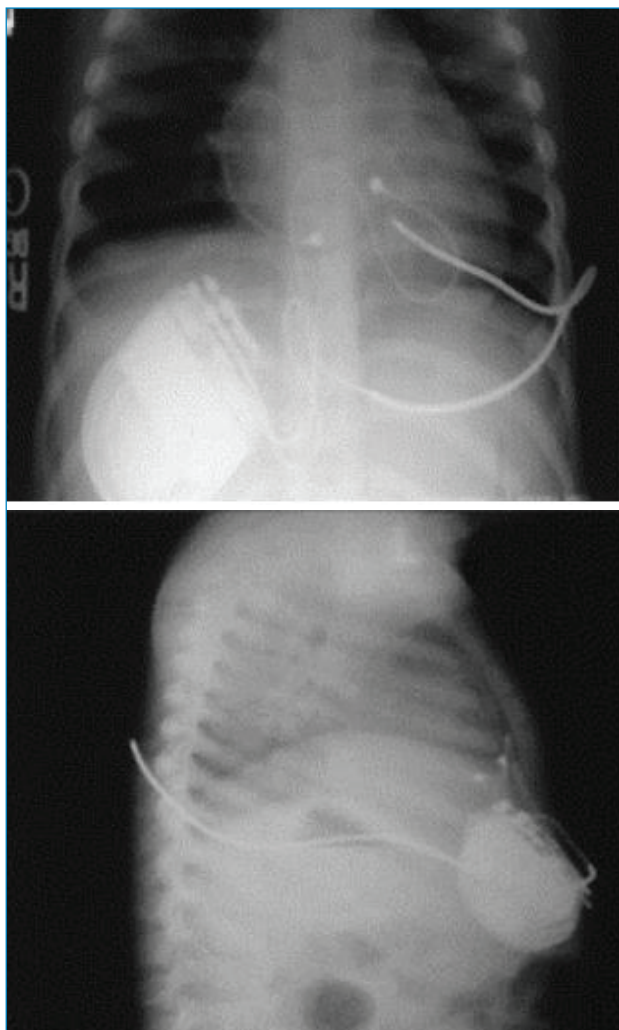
Chest radiography showing subcutaneous defibrillation lead implantation (Medtronic Subcutaneous Lead Model 6996SQ) associated with bipolar pacing/epicardial sensitivity lead in children⁴¹.
